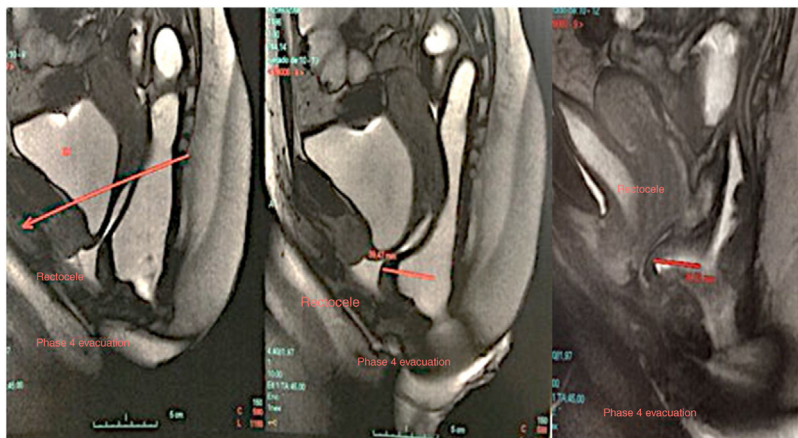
Pelvic MRI defecography showing a rectocele during the evacuation phase.
